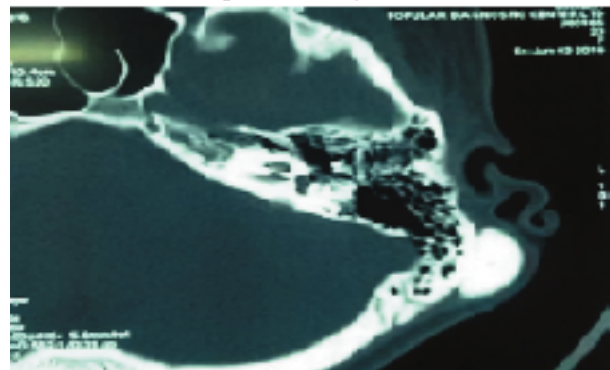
CT scan revealed a focal thickening at the outer aspect of the left mastoid process.
